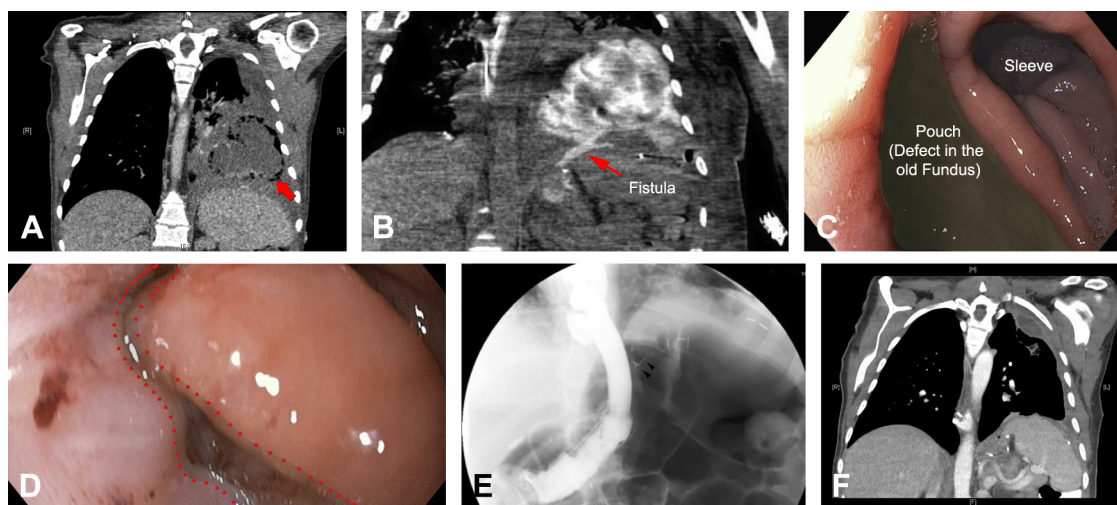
A, Coronal cut of a CT scan without contrast medium revealing an 8-cm abscess in the left lung (*arrow*). B, Coronal cut of a CT scan with contrast medium revealing a leak from a gastropleural fistula into the chest cavity (*arrow*). C, Endoscopic view showing the expanded remnant gastric pouch (*green highlight*) and the gastric sleeve (*red highlight*) separated by a sharp angulation. The gastric pouch appears enlarged secondary to the flow of food and gastric juice caused by the angulation. D, Endoscopic view of the reduced and sutured gastric pouch (*highlighted*). E, Follow-up upper GI barium study revealing adequate closure of the fistula and the gastric pouch. Overstitch endoscopic sutures (*arrowheads*) were used, and 2 fully covered stents overlapping at the site of the previous leak were placed. F, Coronal cut of a CT scan of the chest 6 weeks after the procedure showing complete resolution of the left lung abscess.
